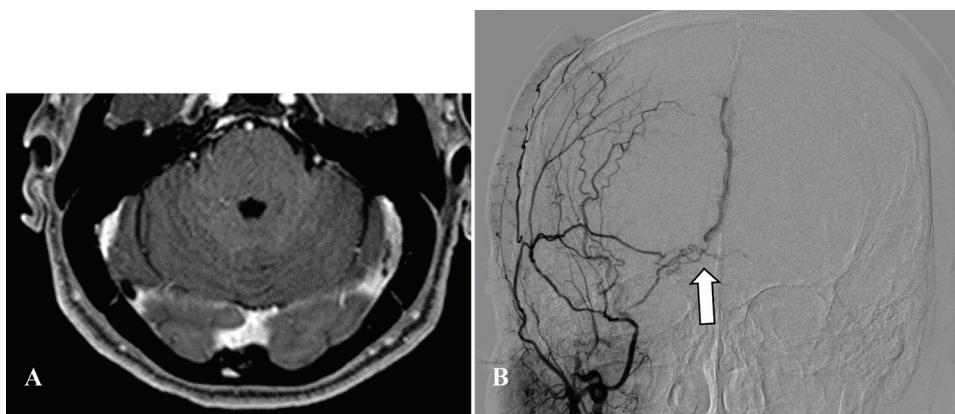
Dural AVF at the torcular herophili. (A) Axial 3D contrast-enhanced THRIVE MRI shows no evidence of dural AVF. (B) DSA reveals small dural AVF at the torcular herophili (arrow), which is fed by petrosquamosal branch of the right middle meningeal artery.
